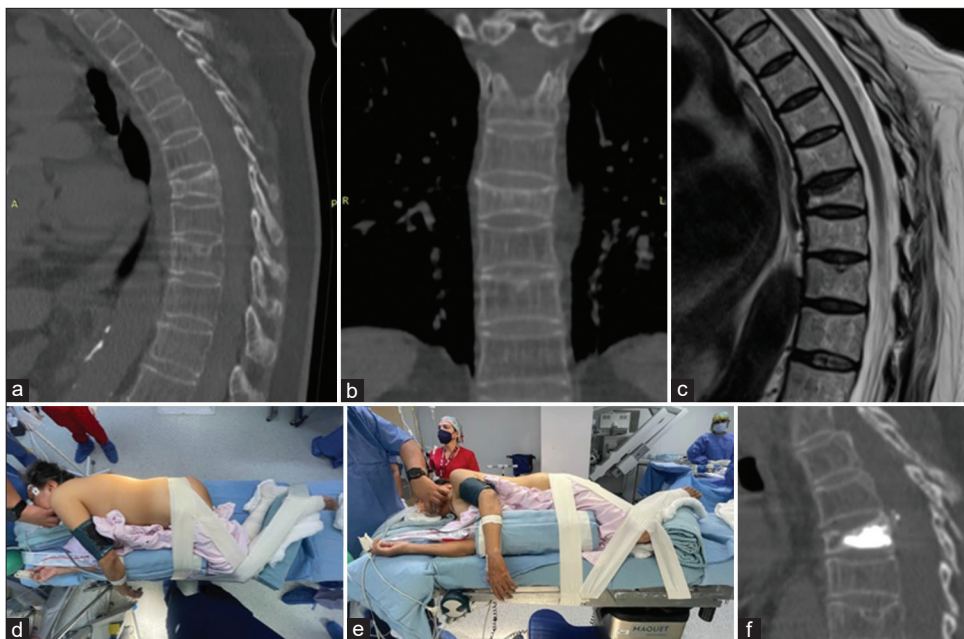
Tomography images (a and b) and magnetic resonance imaging (c) showing vertebral fracture of T7. (d and e): Images of lateral decubitus positioning in the operating room. (f) Postoperative tomography, with the presence of cementation at T7.
